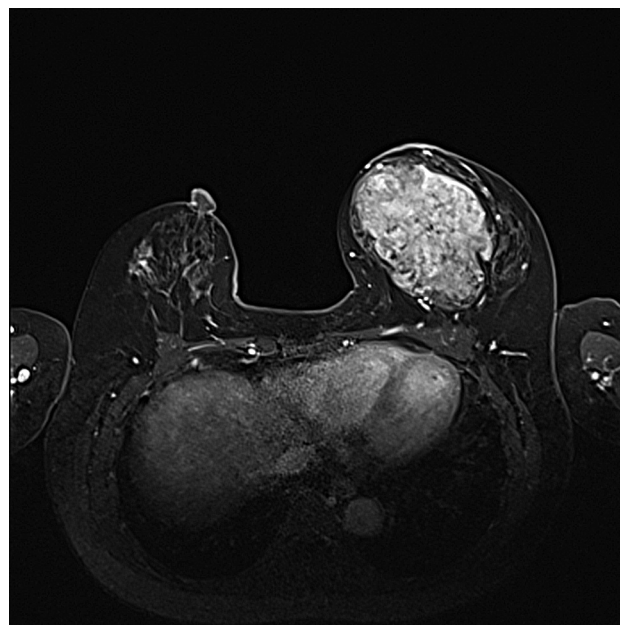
MRI showing carcinoma of the right breast and PT of the left breast.
